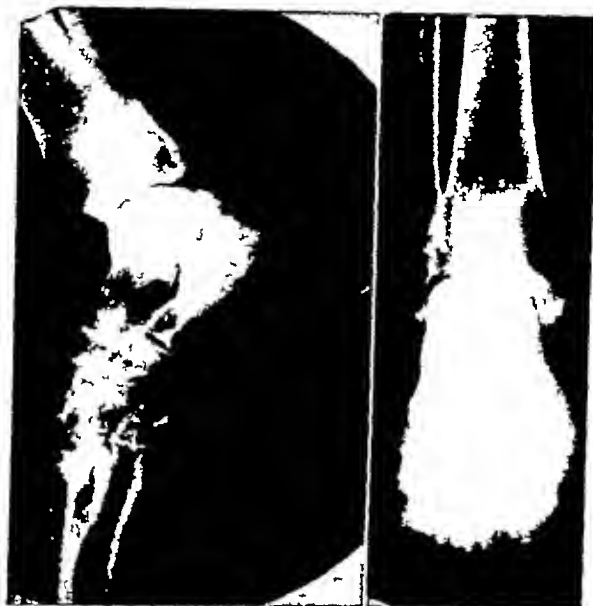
Radiographs of left ankle four months after first examination. Note the stripping of the periosteum of the internal malleolus also the advanced destruction of the os calcis the involvement of the talus, and the moth-eaten appearance of the cuneiforms, cuboid and the bases of the metatarsals
